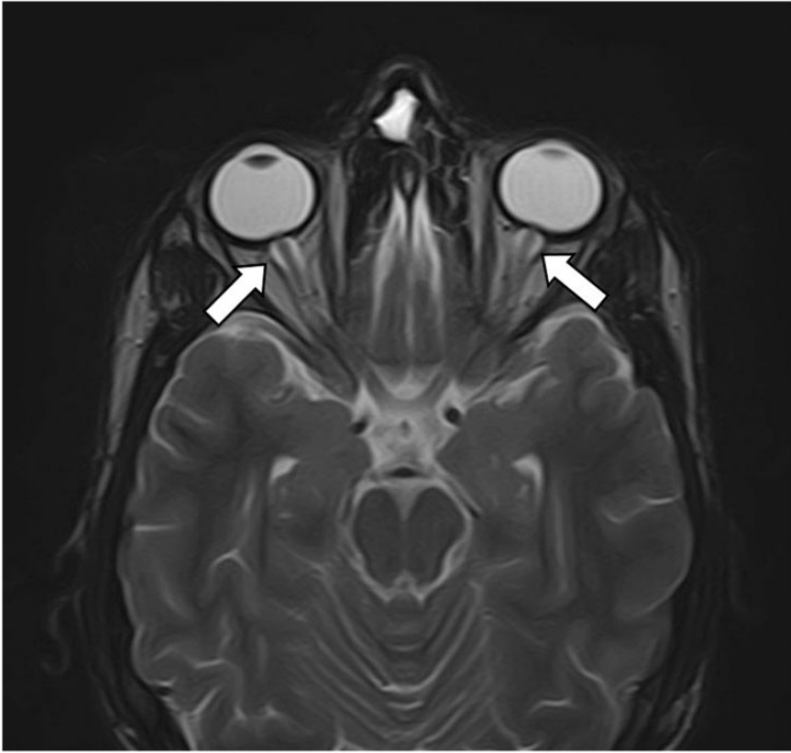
Transverse plane magnetic resonance image showing bilateral widening of the fluid space around the optic nerves in an adult male patient with progressive visual field deficit and deteriorating vision in both eyes.
